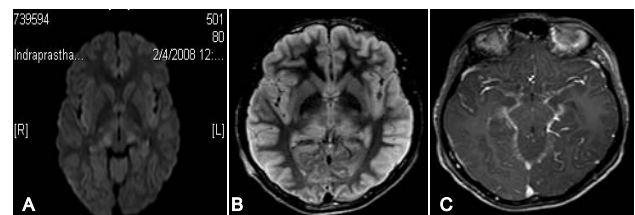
(A) Diffusion-weighted scan showing restricted diffusion in bilateral thalami. (B) Corresponding FLAIR images showing bithalamic hyperintensity. (C) T1-weighted contrast enhanced image showing mild meningeal (basal cistern) enhancement.
